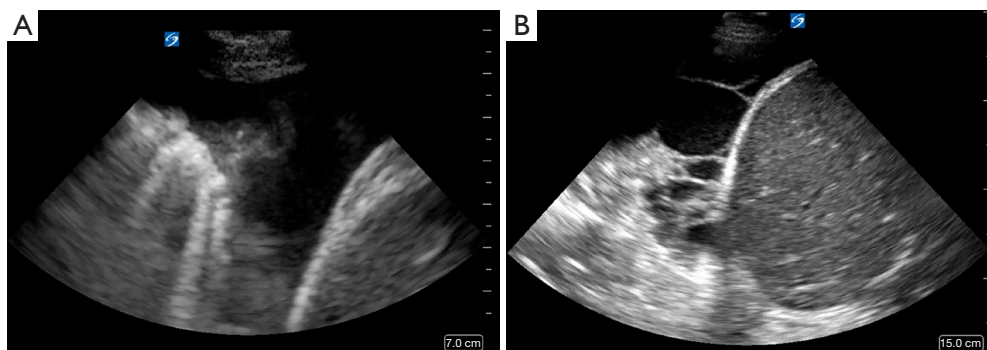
(A) Simple appearance on ultrasound evaluation. This requires diagnostic thoracentesis (*Video 1*). (B) Complex appearance on ultrasound evaluation. This requires chest tube drainage (*Video 2*).
